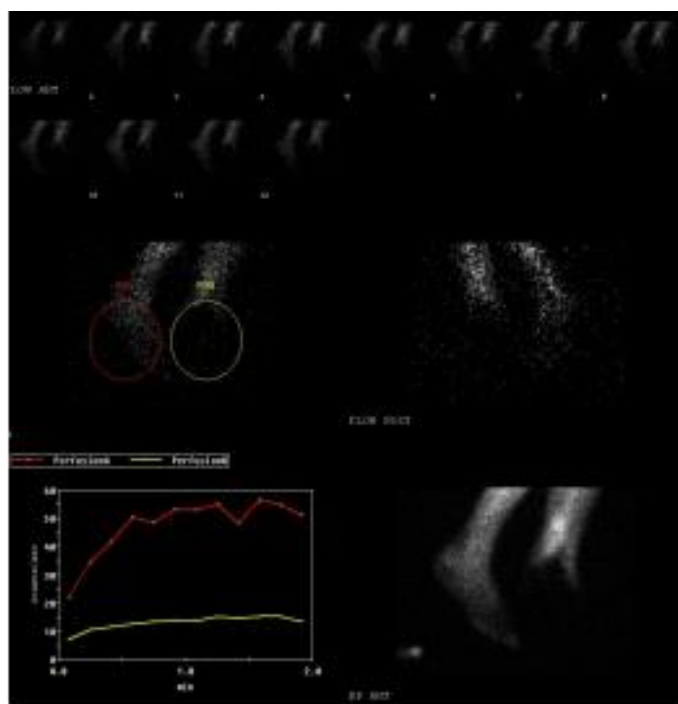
Tc-99m sestamibi organ perfusion scintigraphy of 65-year-old male patient. Percutaneous Transluminal Angiography performed prior to treatment with the value determined by the left peroneal artery stenosis 90%. Perfusion scintigraphy in the work of the left lower extremity defect. Left lower limb perfusion reserve prior to treatment was <10%.
